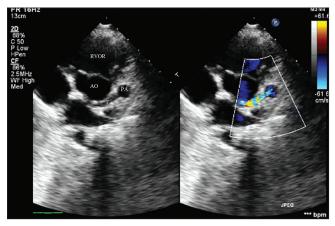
Transthoracic echocardiography in parasternal short axis at the level of great arteries demonstrated the fistula arising from LCX and draining in to PA. LCX = left circumflex coronary artery, PA = pulmonary artery
